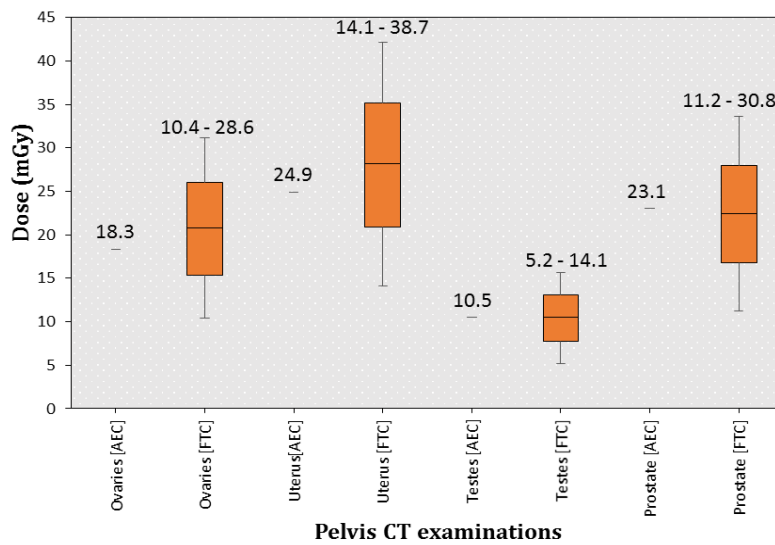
Organ doses for pelvis computed tomography examinations
